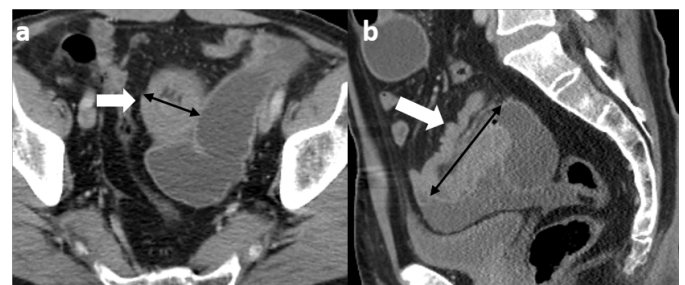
Axial contrast-enhanced CT image demonstrates an ileoileal intussusception (white arrow) and the measurement of its transverse diameter (black arrow) (a). Sagittal contrast-enhanced abdominal CT image shows the ileoileal intussusception (white arrow) with measurement of its longitudinal length (black arrow) (b).
